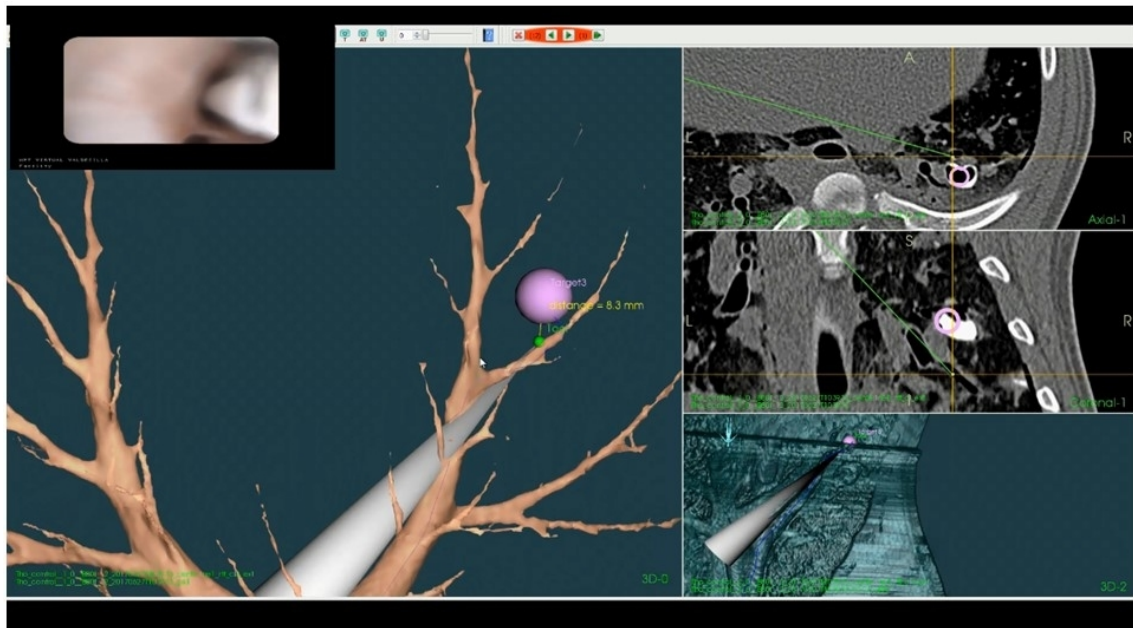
Virtual navigation of the tracked catheter is shown to tumour model *A4* located in the caudal (lower) right lobe. Virtual navigation was achieved to within 8.3 mm of the virtual fiducial in this case. CT image palettes on the right of the screen clearly indicate the injected tumour model which coincides with the position of the virtual fiducial marker. The marking coil is deployed through the working lumen of the tracked catheter. It should be evident that the endoscopic video view (top right inset) is not useful in navigating to such peripheral and transbronchial targets as the bronchoscope diameter (6.3 mm) is too large to pass to the outer airways (2-4 mm).
